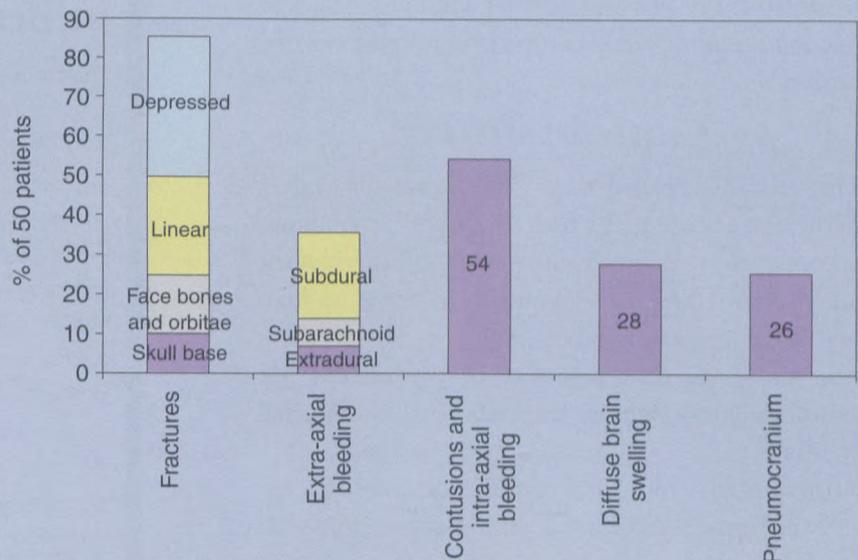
Findings in 50 patients with an abnormal trauma related CT.
